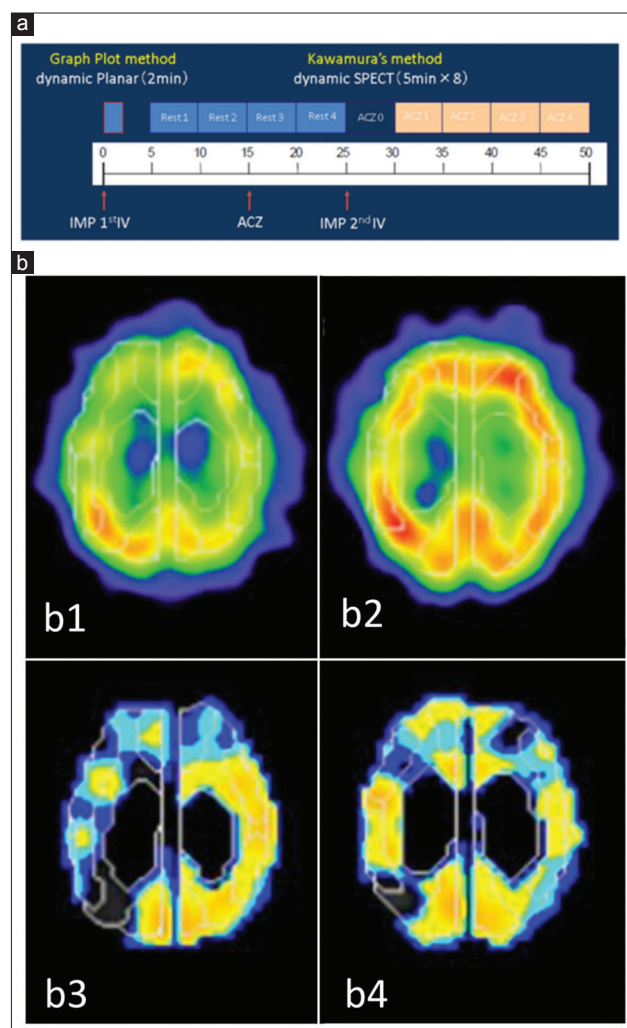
(a) Protocol of the IMP-RAMDA method. (b) SPECT images in a 77-year-old man with stenosis of the right carotid artery. Preoperative cerebral blood flow in the resting state determined by SPECT (b1) and postoperative cerebral blood flow in the resting state determined by SPECT (b2). Preoperative image of cerebrovascular reactivity determined with IMP-RAMDA method (b3) and postoperative image of cerebrovascular reactivity determined with IMP-RAMDA method (b4). Preoperative SPECT showing low cerebrovascular reactivity in the right hemisphere and the value was 11.83 (b3). Postoperative SPECT revealed increased cerebrovascular reactivity on the side of carotid artery stenting and the value was 26.44 (b4). IMP: *N*-isopropyl-*p*-iodoamphetamine; RAMDA: Rest and true acetazolamide images estimated method using dynamic acquisition; SPECT: Single-photon emission computed tomography; ACZ: Acetazolamide.
